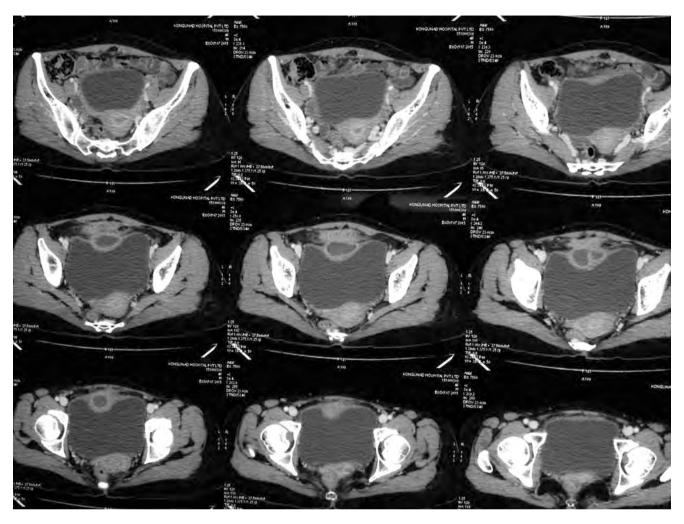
CT image showing urachal cyst
